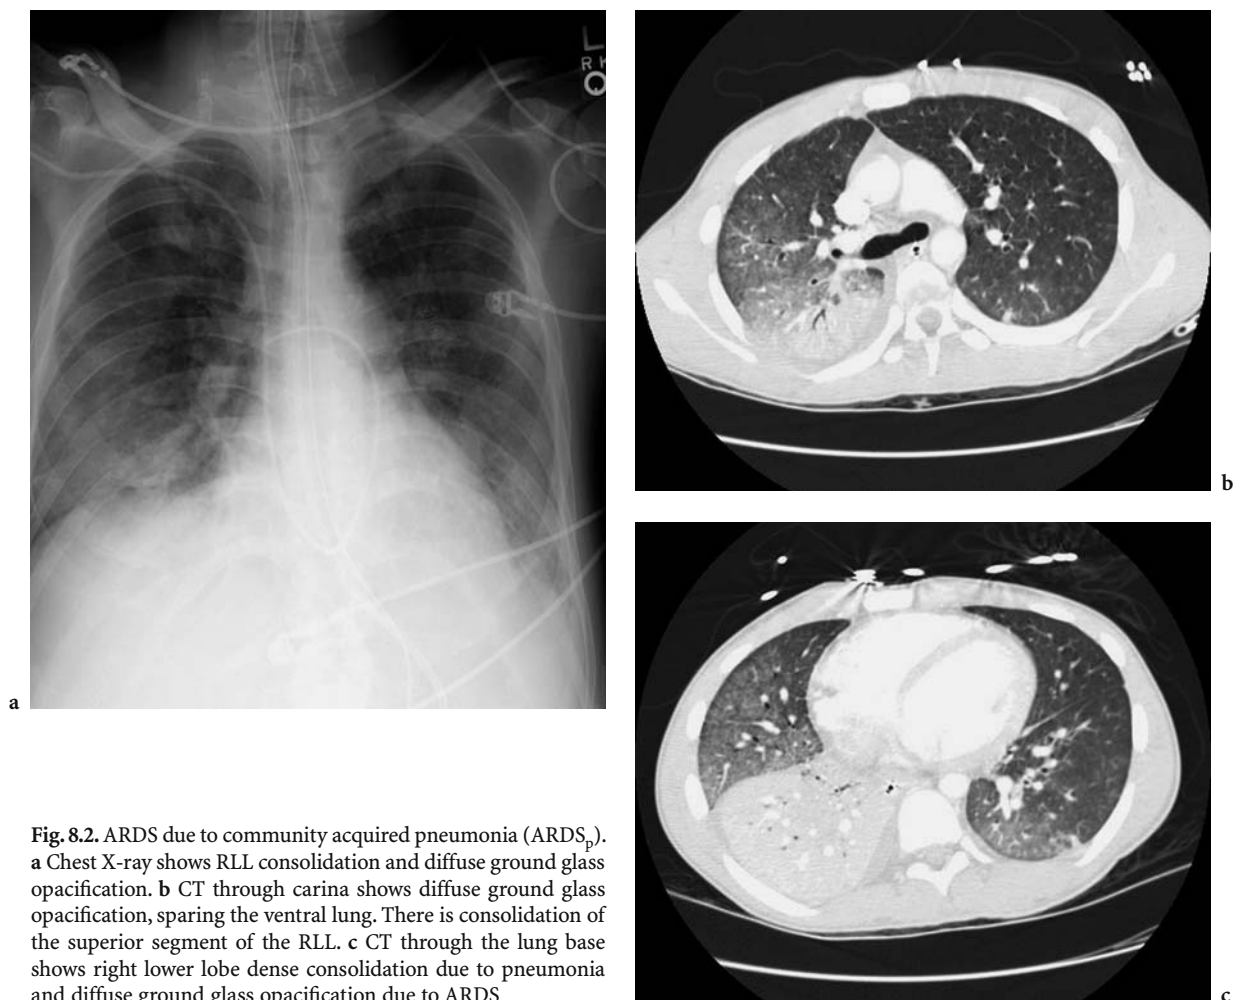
ARDS due to community acquired pneumonia ($ARDS_p$). a Chest X-ray shows RLL consolidation and diffuse ground glass opacification. b CT through carina shows diffuse ground glass opacification, sparing the ventral lung. There is consolidation of the superior segment of the RLL. c CT through the lung base shows right lower lobe dense consolidation due to pneumonia and diffuse ground glass opacification due to ARDS
